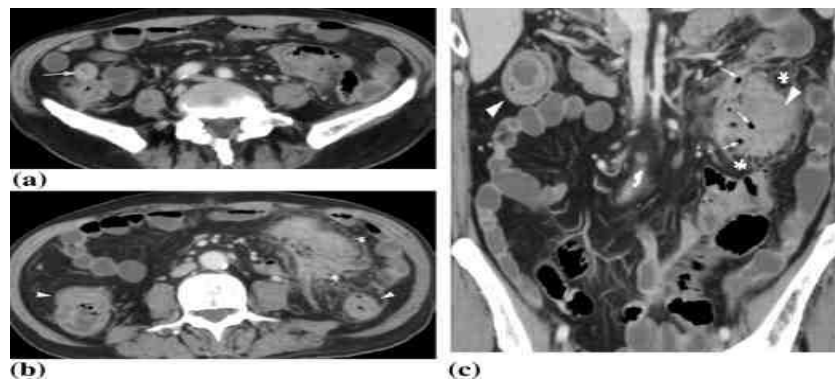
Male patient of age 28 years old, with 2 year history of Crohn’s disease. CT enterography (axial a & b, coronal c) revealed active Crohn’s disease with mural thickening and hyper enhancement involving the terminal ileum (arrow) and most of the large bowel (arrowheads). The splenic flexure is the seat of pericolic inflammatory process with stranding of the pericolic fat (asterisk) and multiple air locules (thin arrow) are noted, consistent of a “phlegmon”.
